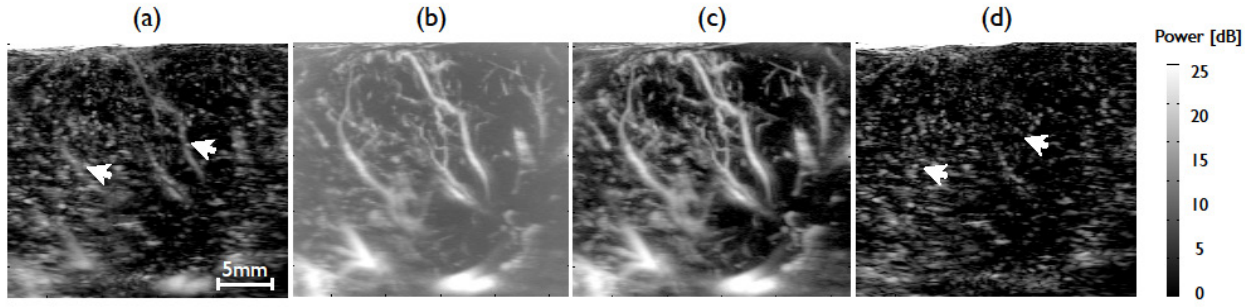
Vessel and perfusion segmentation using signal coherence in a VX-2 tumour perfused by microbubbles. (a) Contrast-enhanced (AM) images highlighting all blood. (b) Nonlinear power Doppler using conventional $R(0)$ power detection segmenting flow. (c) Nonlinear power Doppler with suggested $|R(1)|$ detection improving SNR by ~ 12 dB. (d) Long lag $|R(50)|$ contrast power detection highlighting perfusion-only.
